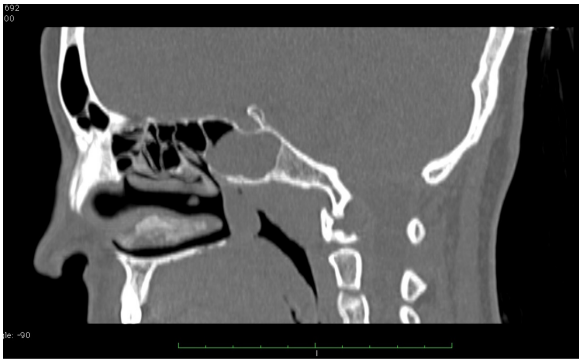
Coronal computed tomography scan showing a homogenous soft tissue mass almost filling the left sphenoid sinus cavity and extending in the posterior nasal cavity.
